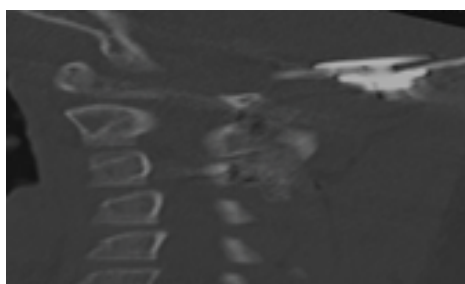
Sagittal CT of the cervical spine demonstrating the bolt/nut construct in the appropriate location despite the thin bone in the pediatric occipital region.
